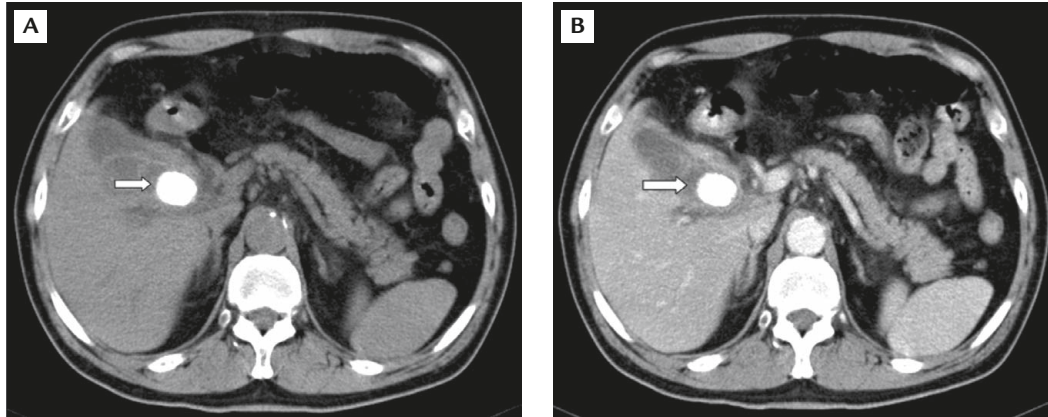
(A) Non-contrast-enhanced computed tomography (CT) and (B) contrast-enhanced CT demonstrated fluid collection at the gallbladder fossa and a calcified gallstone (arrow) in the neck.
